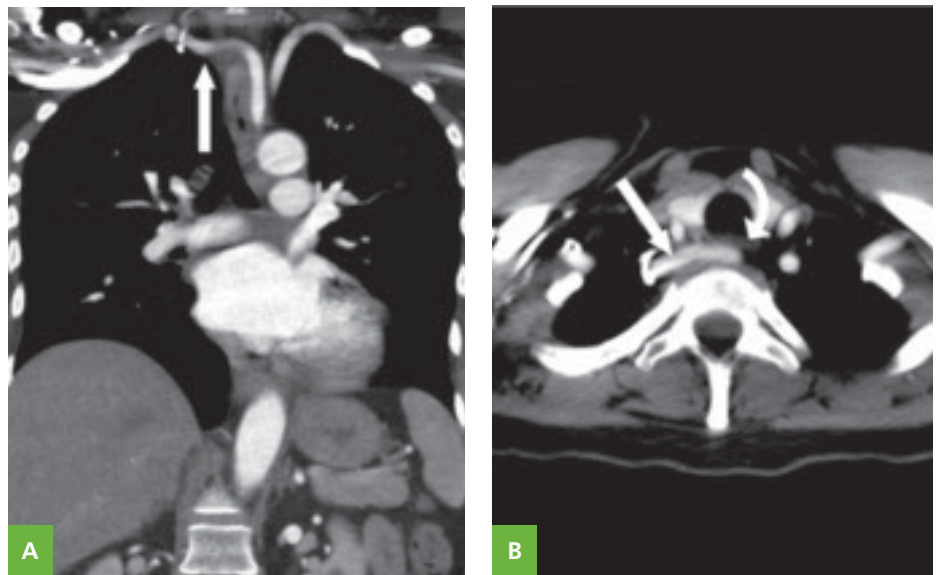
Thoracic angiogram CT images showing an aberrant right subclavian artery (ARSA). A, Coronal reformatted image of CT thoracic angiogram indicating RSA (arrow). B, Axial image of CT thoracic angiogram showing ARSA (straight arrow) traversing left to right immediately in front of thoracic spine and posterior to the trachea and esophagus (curved arrow), which is compressed between the trachea and the ARSA.
